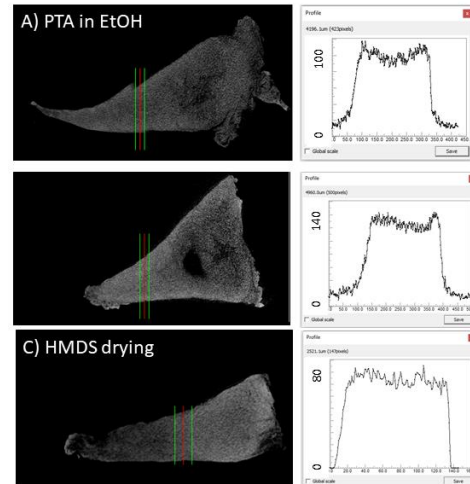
menisci CE- $\mu$ CT sections and grey levels contrast profiles along red lines
